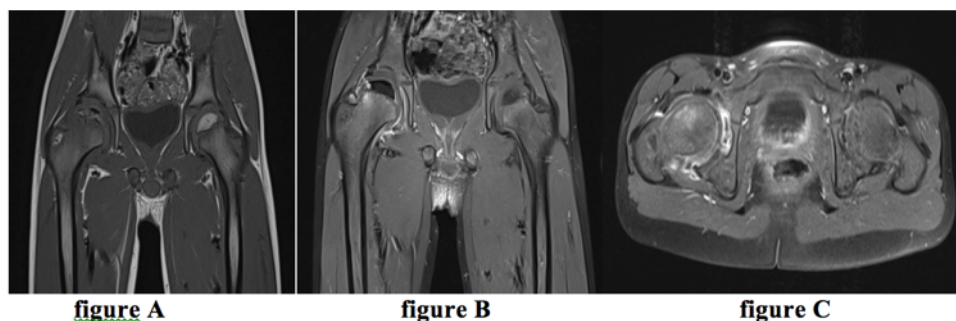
7-year-old child who has been limping for 3 months in a context of apyrexia MRI of the hip in coronal T1 (Figure A), coronal T1 with injection of PDC (Figure B) and T1 FS gado (Figure C) showing irregularity and erosions of the right femoral head with subchondral geodes and transphyseal enhancement associated with thickening and reactive synovial enhancement related to osteochondritis.
